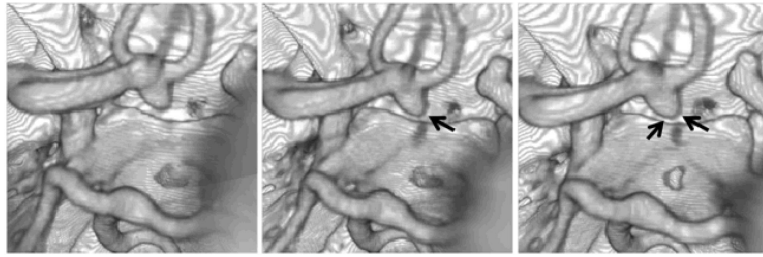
Volume rendered longitudinal CTA images at three time points during the evolution of a growing cerebral aneurysm at the anterior communicating artery. Arrows point to the enlarging regions.
